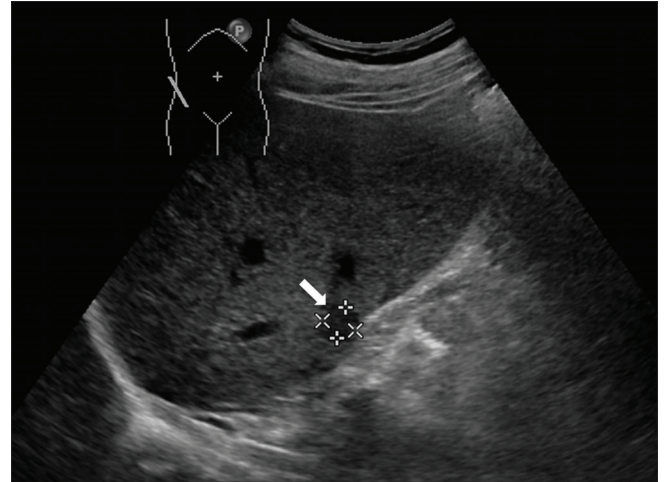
Axial view of an ultrasound image of the liver which showed almost complete resolution of the segment VI abscesses (bold white arrow) following administration of intravenous ceftazidime and percutaneous drainage
